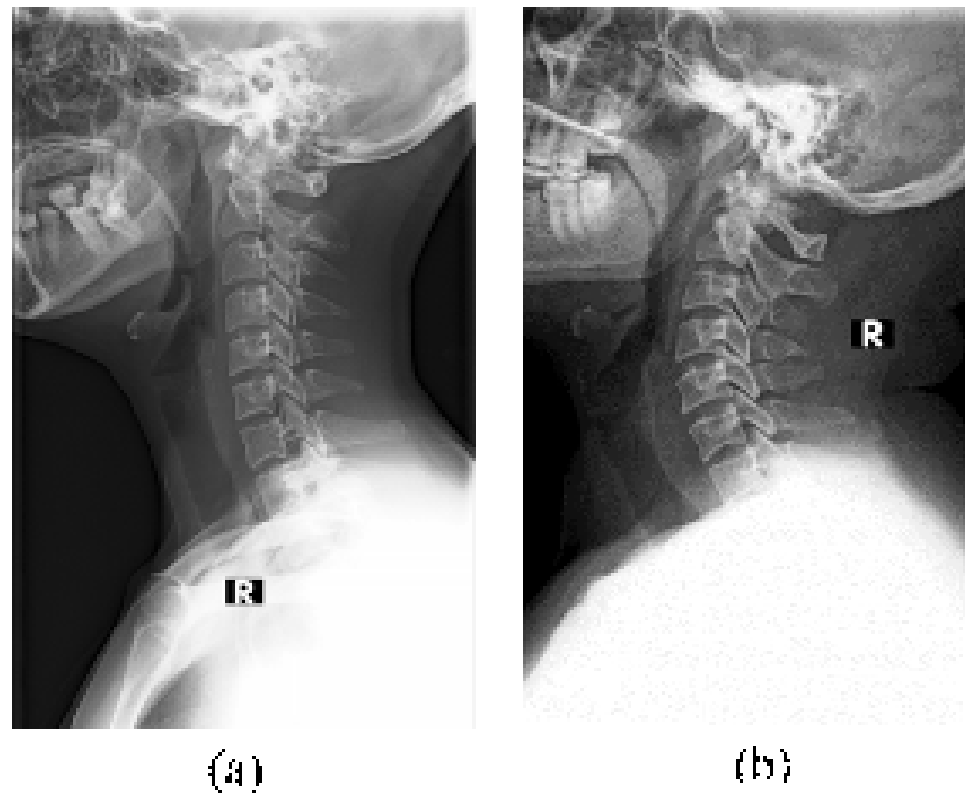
Erect lateral cervical spine radiographs. (a) The lower cervical spine and the C7-T1 junction are not obscured by the musculoskeletal structures. (b) The lower cervical spine and the C7-T1 junction are obscured by the musculoskeletal structures.
